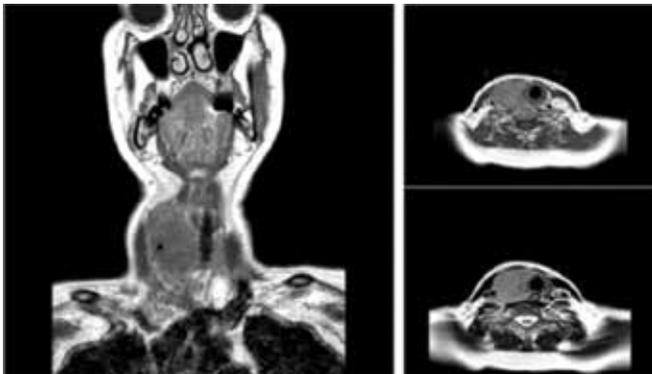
a, b, c: Neck MRI: Enlargement of the right lobe of the thyroid, 5x4.5x3.5 cm sized T1W hypointense, T2W hyperintense nodular lesion occupying right lobe with homogeneous contrast uptake.
